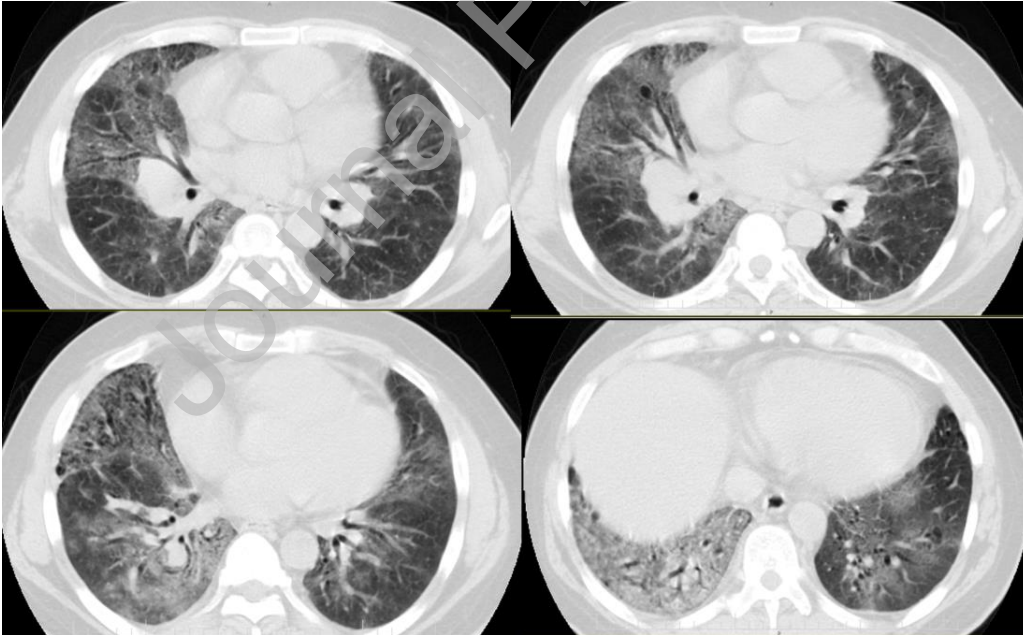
Four axial CT scan show ill-defined bilateral ground-glass opacities (GGO) and bronchial dilatation within areas of GGO bilaterally and a small air cyst in the right middle lung lobe, suggestive of an early stage ARDS due to COVID-19 pneumonia subsequently confirmed by PCR test.
